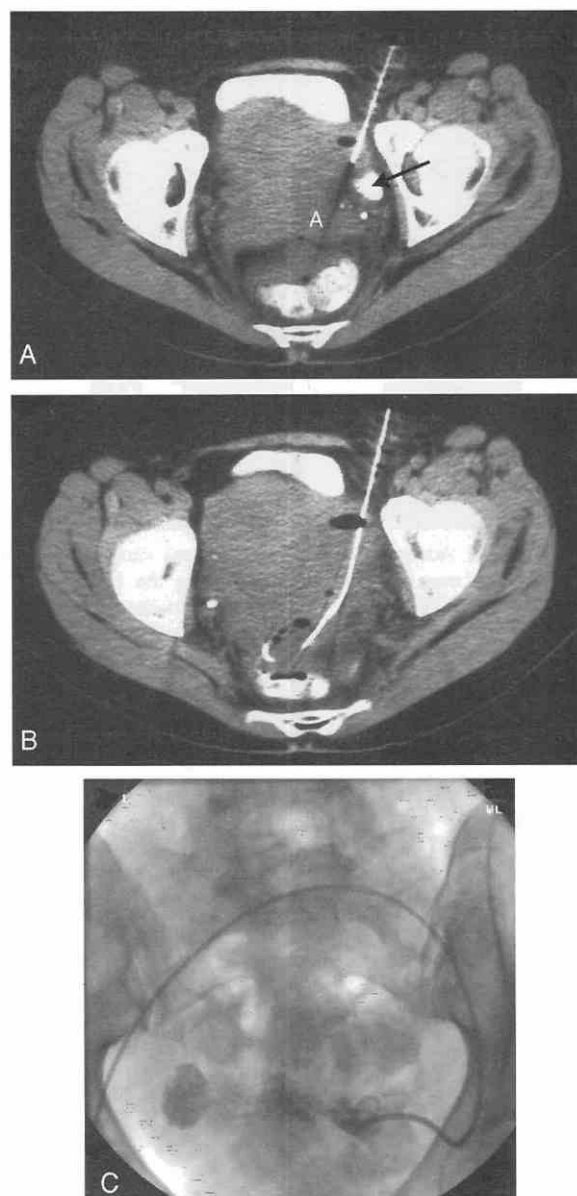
A, Scan shows an approach to an abscess (A) posterior to the bladder and adjacent to sigmoid colon (arrow) from diverticular abscess. B, Scan shows insertion of a wire throughout the length of the cavity. C, Radiograph shows the injection of contrast material, demonstrating a fistula to diverticulum of colon.
